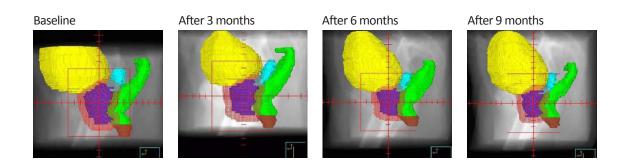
Prostate volume reduction (purple) shown on sagittal plane of CT scans after different months of Maximal Androgen Blockade (MAB).
